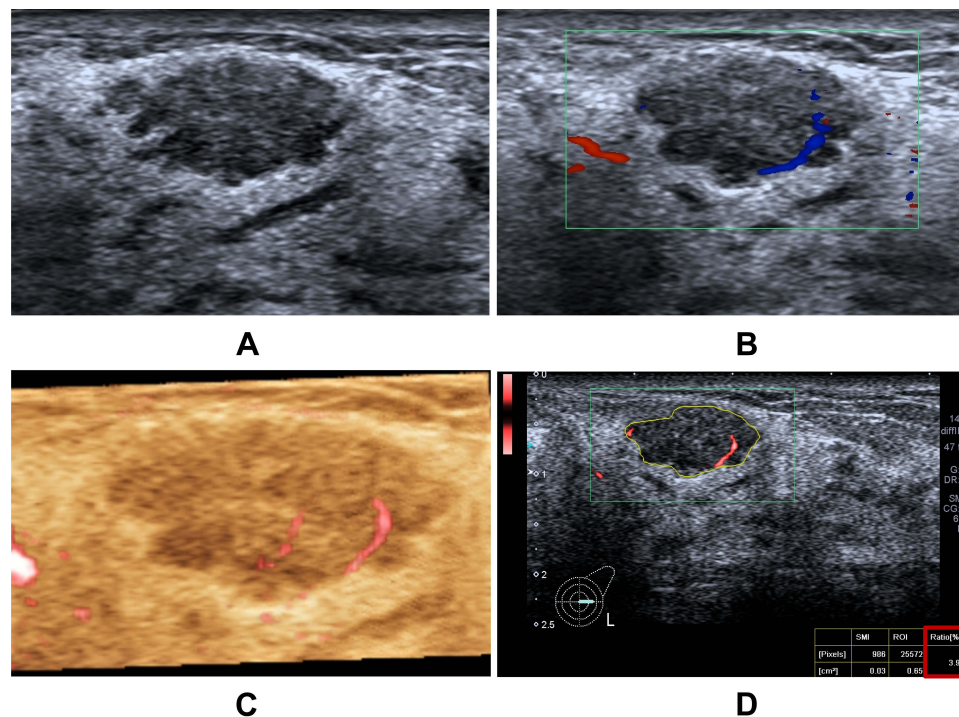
A 34-year-old woman with mammary adenosis which be downgraded to BI-RADS 3. (A) Grayscale ultrasonography shows an irregular or microlobulated hypoechoic lesion in the left breast, which was assessed as BI-RADS category 4A. (B) CDFI shows a linear vessel within the mass. Green box: CDFI sampling frame. (C) SMI shows regular linear vessels within the lesion. (D) When the ROI is set as the entire target lesion (yellow line), the vascular index of the mass is 3.9% (red box). Green box: SMI sampling frame.
